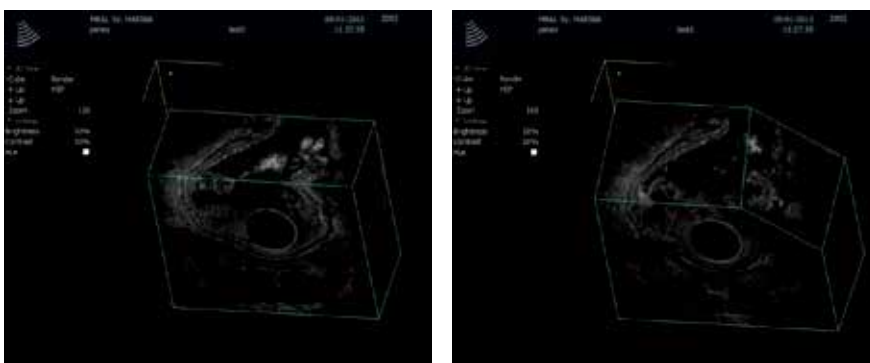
Endorectal ultrasonography – a view of T-3 carcinoma - 3-D reconstruction after real-time software rendering.
